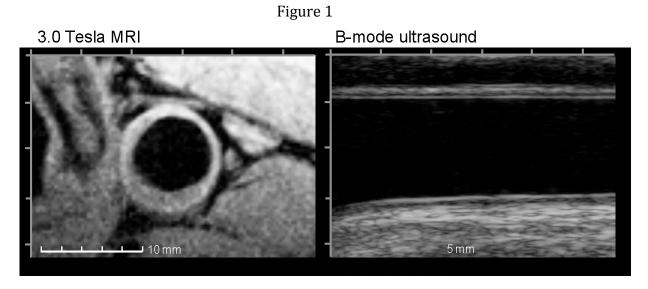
Carotid MRI (left) and carotid ultrasound (right).
